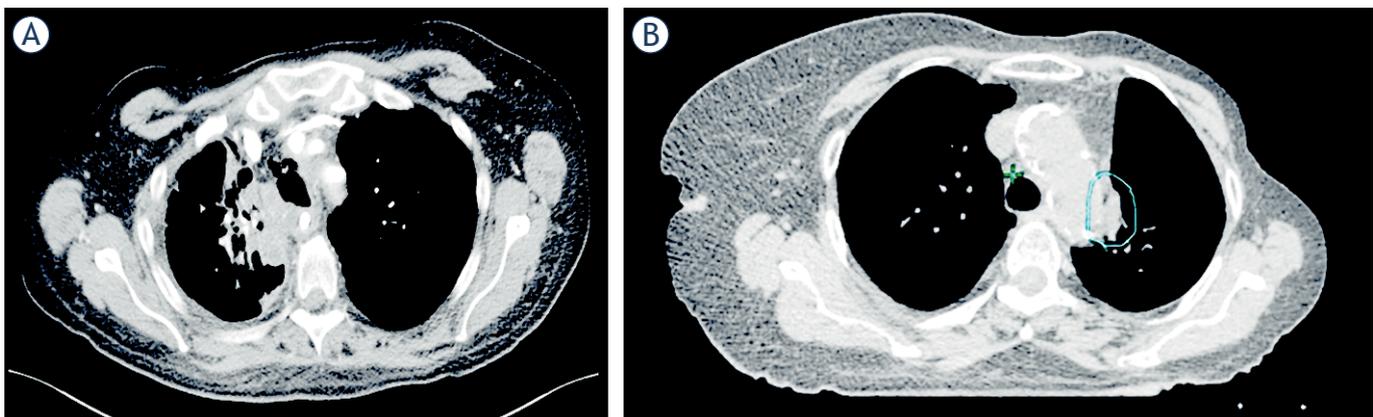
Computed tomographic imaging examples of patients with a grade 3 or higher toxicity. (A) Patient with a tracheal rupture after reirradiation. (B) Patient with vocal cord paralysis after reirradiation (previous chest wall radiotherapy). The circled portion indicates the planning target volume.
